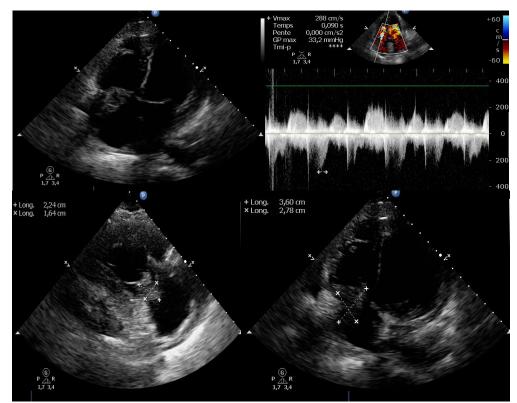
Echocardiography showing an image of vegetations on the atrial side of the tricuspid valve
